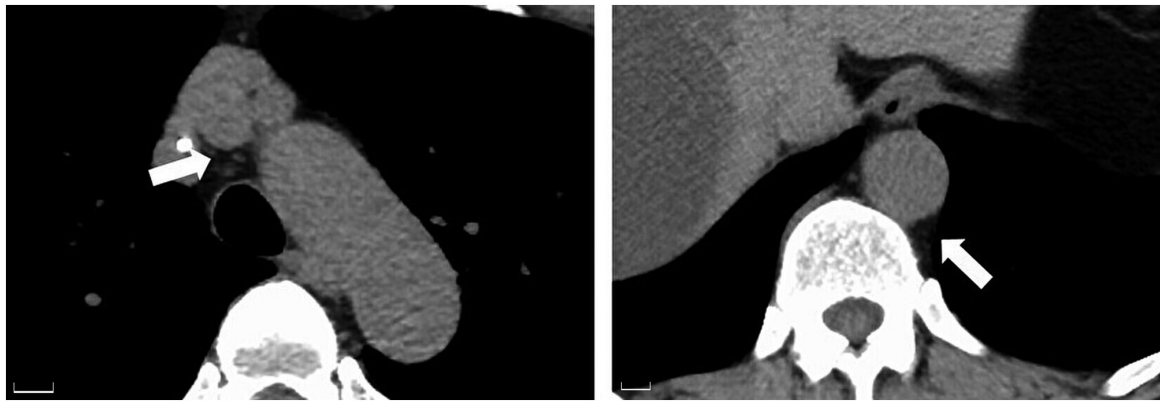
Computed tomography scan findings two months after granulocyte-colony stimulating factor discontinuation. Periaortic soft tissue inflammation around the brachiocephalic artery (left) and abdominal aorta (right) showed improvements. Scale bars, 1 cm.
